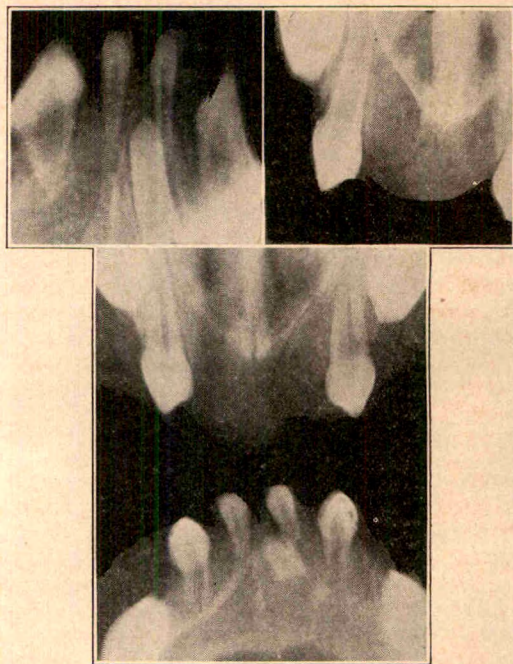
Intraoral roentgenogram in ectodermal dysplasia.
